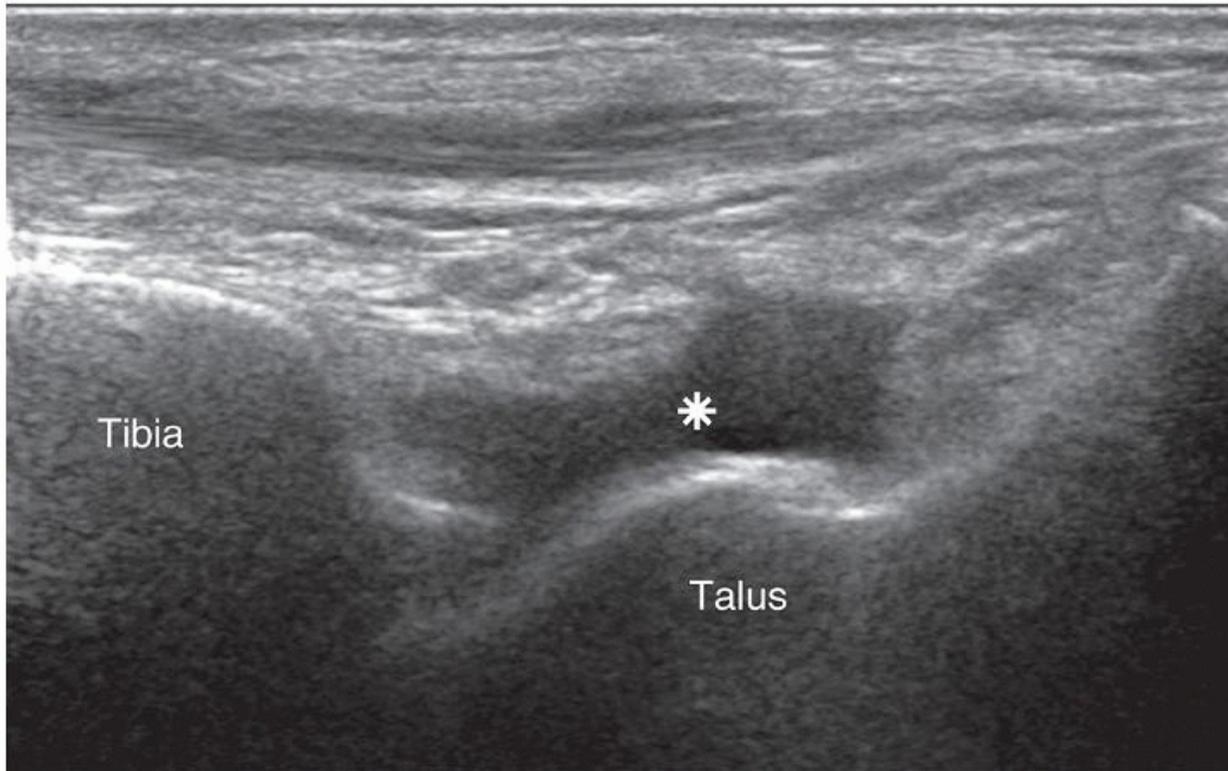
Longitudinal ultrasound anterior aspect of ankle. There is a moderate ankle joint effusion (asterisk) displacing the anterior fat pad.
